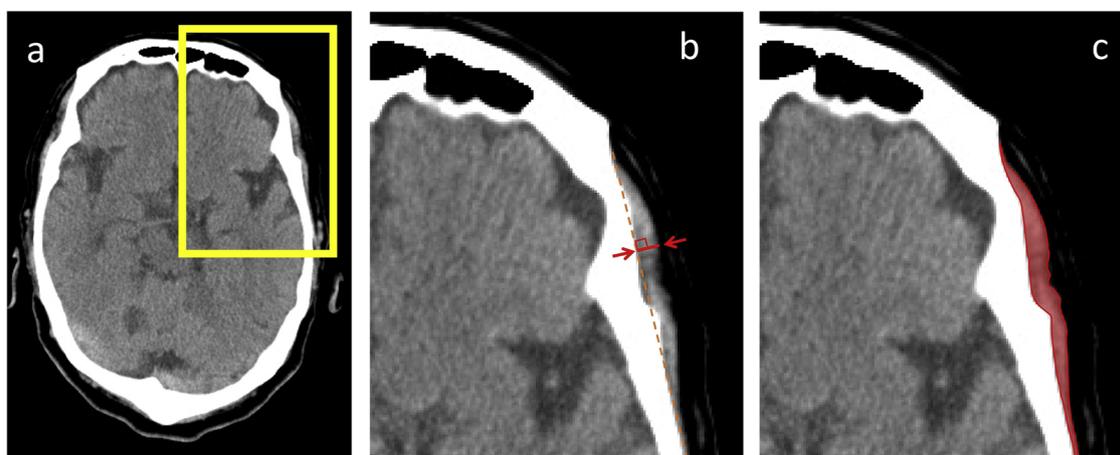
Measuring temporal muscle thickness and area on the head computed tomography (CT) image. The slice is 5 mm above the superior wall of the orbit. (a) CT image representing temporal muscle thickness. (b) CT image representing the temporal muscle area. (c).
